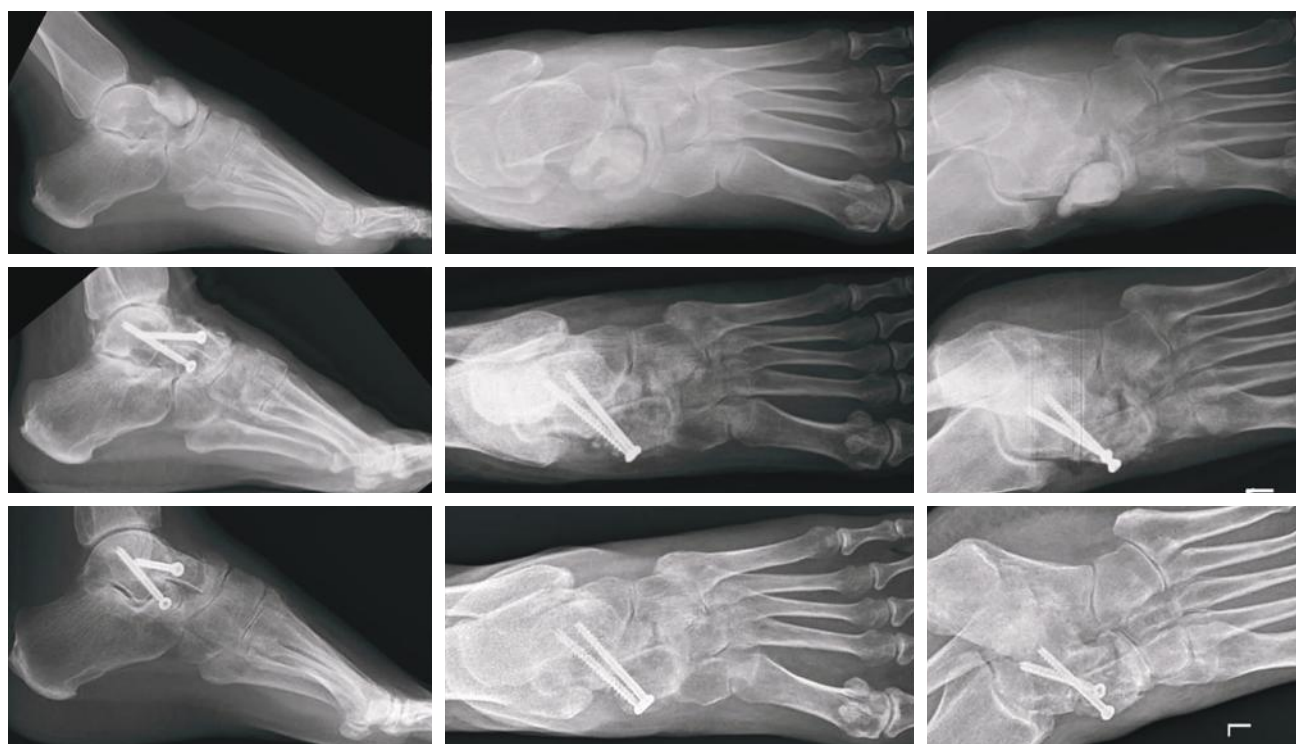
Comparative radiographs of the affected foot in lateral (*left*), anteroposterior (*center*), and oblique (*right*) views. Top row: Radiographs after the index surgery demonstrating persistent talonavicular joint destruction. Middle row: Immediate post-operative radiographs following definitive talonavicular arthrodesis with screw fixation. Bottom row: Radiographs at 4-month follow-up demonstrating maintained alignment, stable hardware, and progressive osseous fusion across the arthrodesis site.
